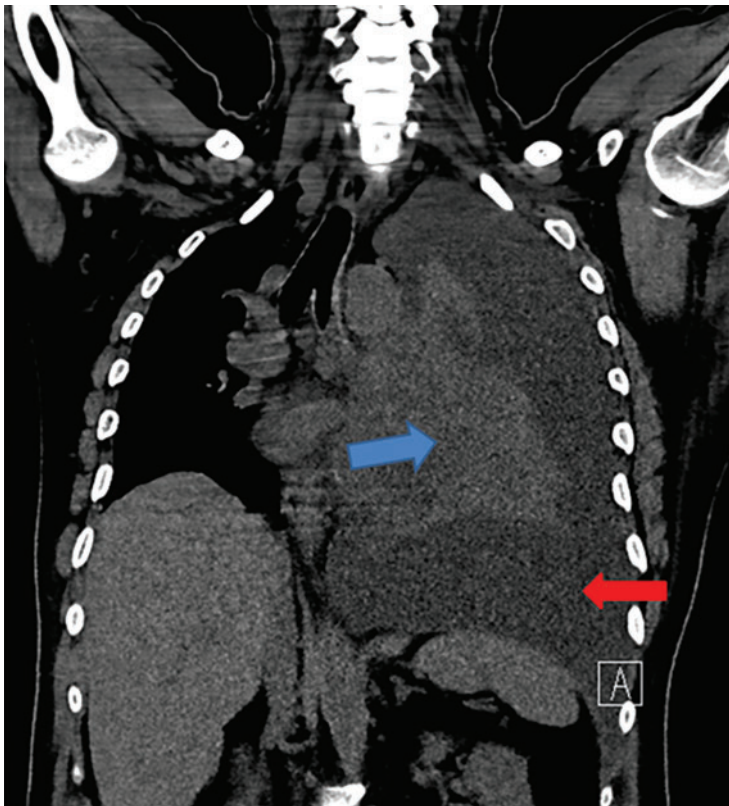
Coronal computed tomography shows left-sided pleural effusion (red arrow) and collapsed lung (blue arrow), along with midline shift.
